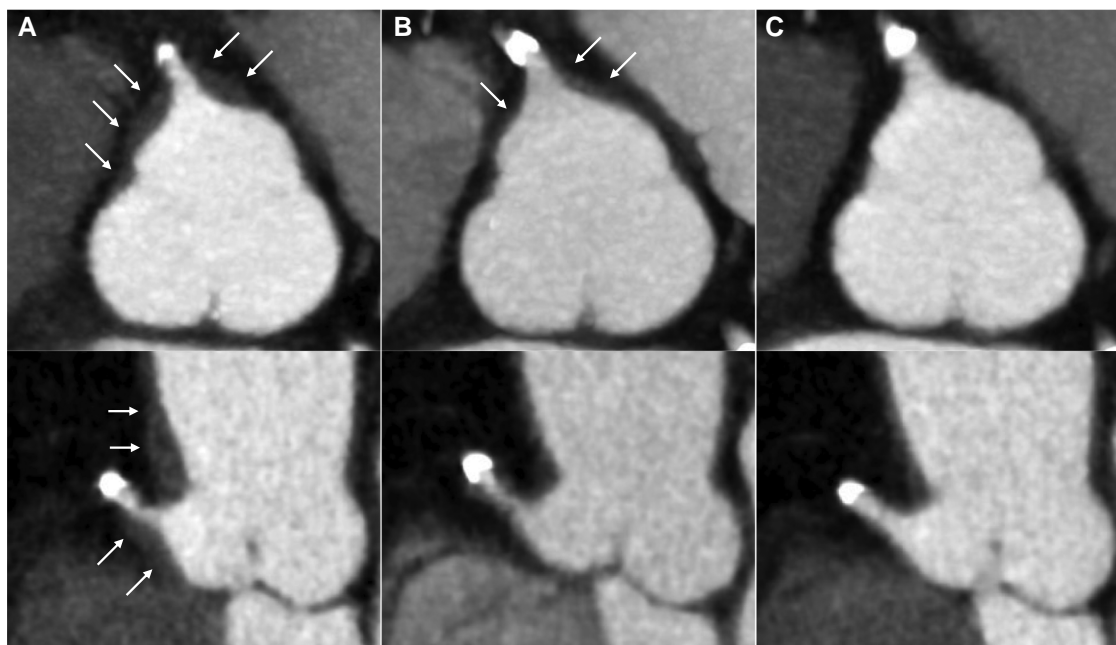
Follow-up coronary computed tomography (CCT). (A) Initial CCT performed on the following day of an elective percutaneous coronary intervention showing a residual aortocoronary intramural haematoma (white arrows). (B) Follow-up CCT performed 2 weeks later showing a regression of the haematoma (white arrows). (C) Follow-up CCT performed 6 months later showing a disappearance of the haematoma.
